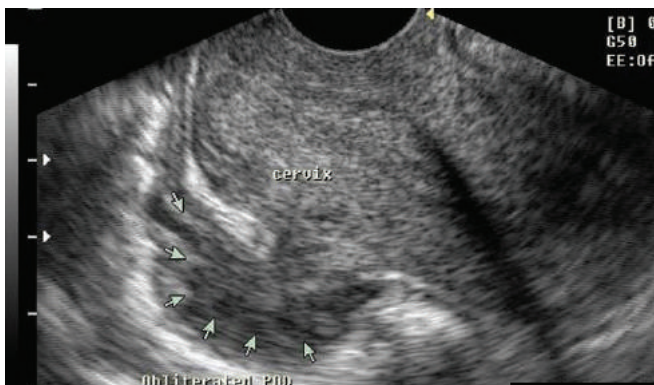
Sagittal endovaginal ultrasound in a case of endometriosis showing moderately echogenic nodule (arrows) with irregular margins lying posterior to the cervix and infiltrating/obliterating the Pouch of Douglas.
